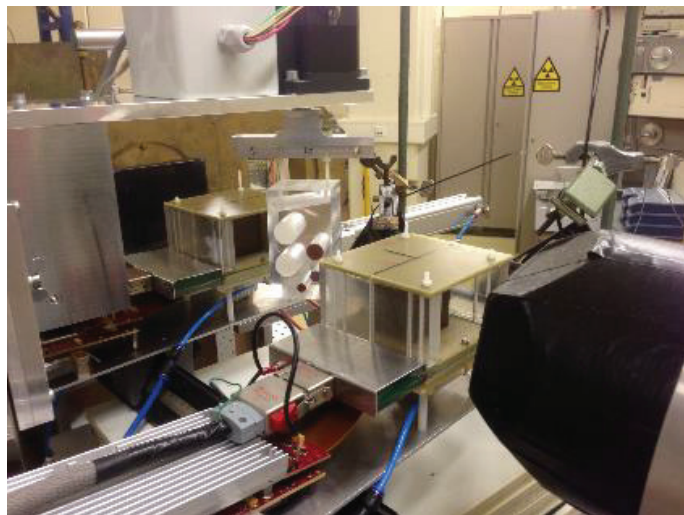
The experimental setup for proton radiography [25].
